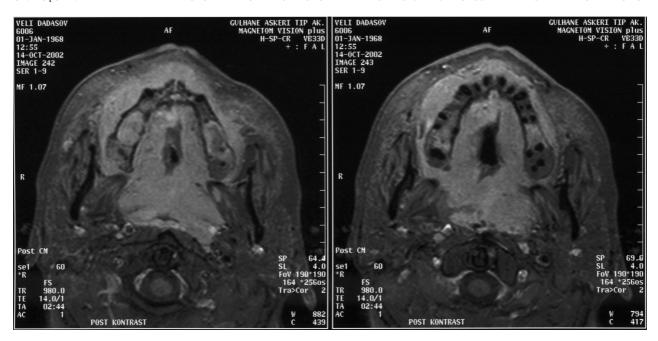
Axial T1 weighted, contrast enhanced MR images showing the disease which involved all paranasal sinuses, orbita, nasal cavity and hard palate.
